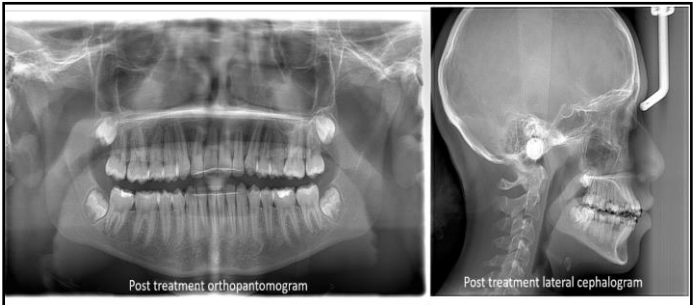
Post treatment Orthopantomogram & Lateral cephalogram
